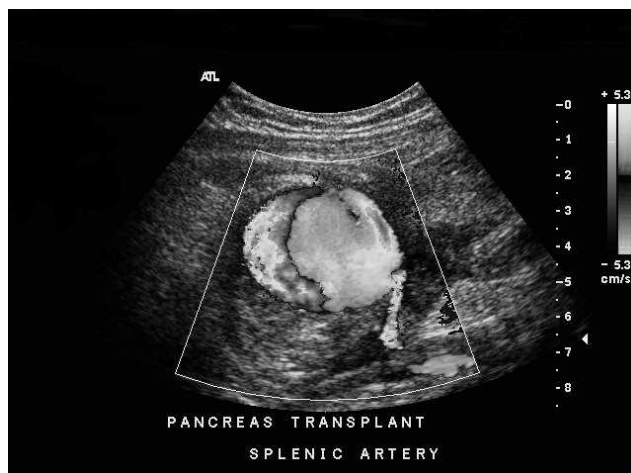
Color-flow Doppler image demonstrating a pseudoaneurysm of the splenic artery.
